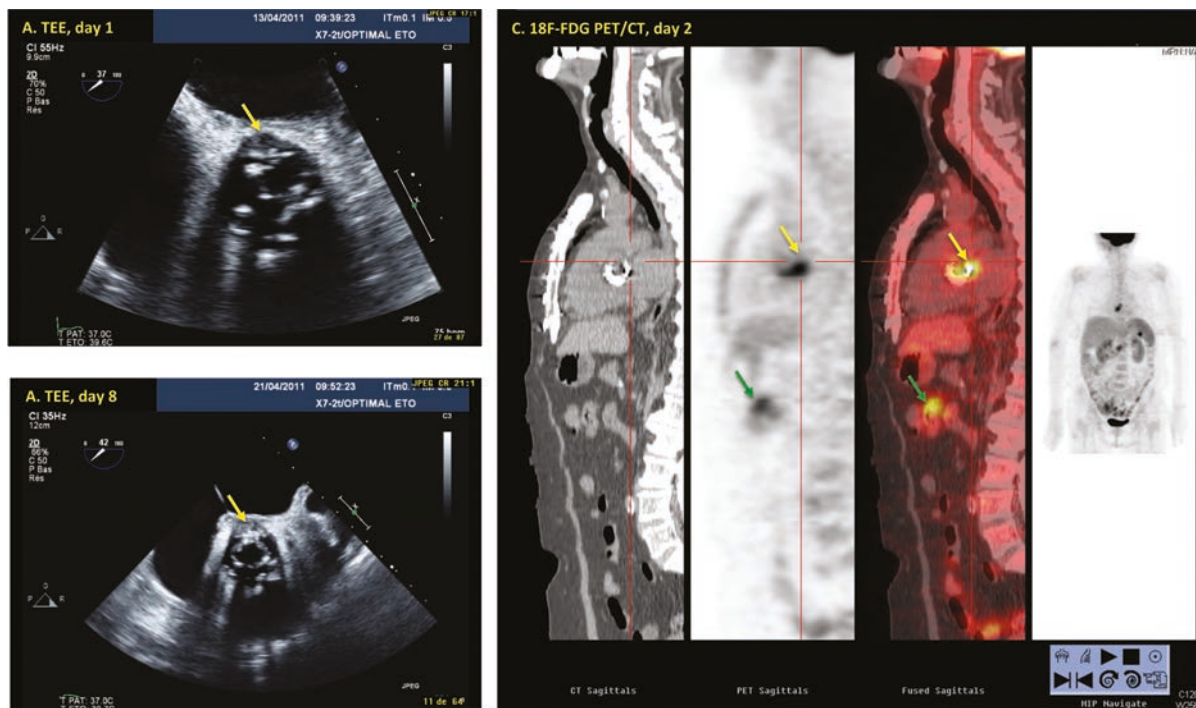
Results of echocardiographic studies and 18F-FDG PET-CT in a case of suspicion of aortic bioprosthetic valve infective endocarditis. The first TEE (a) showed a small doubtful thickening around the aortic bioprosthetic annulus (yellow arrow) in a patient with fever and negative blood cultures. The second TEE (b), performed 8 days after, showed the development of a periprosthetic abscess (yellow arrow). The 18F-FDG PET-CT performed the day after the first TEE showed a hyperfixation around the aortic prosthesis (c, yellow arrow). The patient underwent urgent valve surgery, which confirmed the abscess. Of note, colonic hyperfixation was shown by 18F-FDG PET-CT (green arrow), which reveals a polyp at subsequent colonoscopy.
